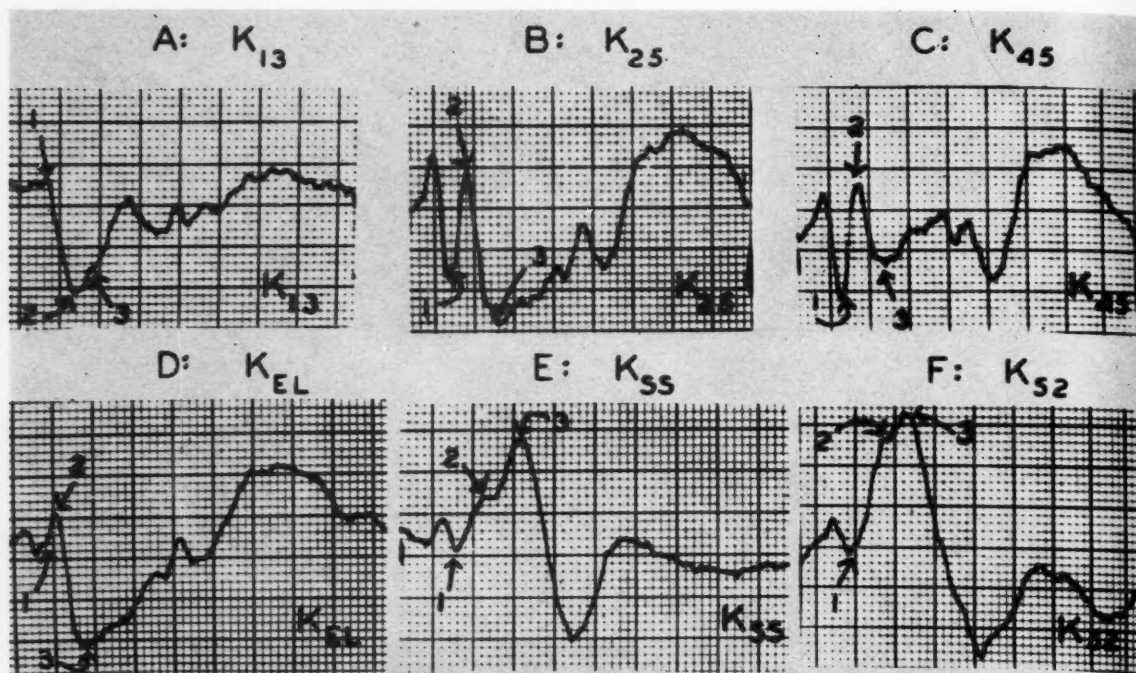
D. G., a normal 26-year-old man. Time lines 0.02 second. The traces begin and end at the onset of the QRS. Note the resemblance of the different records to ventricular volume (B, C, D), arterial pulse (E, F), and atrial pressure (A) traces. As left ventricular ejection begins, three phenomena are noted: (1) A large recoil upstroke is seen over the lower left precordium (first arrow, B and C) and in the epigastrium (first arrow, D). In B this upstroke is preceded by a much smaller one due to right ventricular recoil. (2) The right parasternal record (A) displays a prominent downstroke (first arrow), attributed to descent of the tricuspid leaflets. (3) The suprasternal (E) and high left axillary (F) records exhibit large upstrokes which are attributed to expansion of the aorta and the left subclavian artery, respectively. During the early part of rapid ejection the main inward motion of the left precordial (B and C, second arrow) and of the epigastric (D, second arrow) regions occurs. A little later the small right parasternal upstroke (A, second arrow) ascribed to bulge of the tricuspid leaflets is seen. As reduced ejection begins, a large (A, third arrow) or small (B and C, third arrow) outward motion occurs. This is attributed to rapid filling of the posteriorly situated atria. The descent of the inferior border (D, third arrow) associated with a downward notch in the upper precordial traces (E and F, second arrow) is probably due to descent of the mitral leaflets, or of the aortic annulus (see text). The sharp downstrokes in the suprasternal and upper axillary records (E and F, third arrow) are probably due to runoff of blood from the aorta and from the left subclavian artery.
